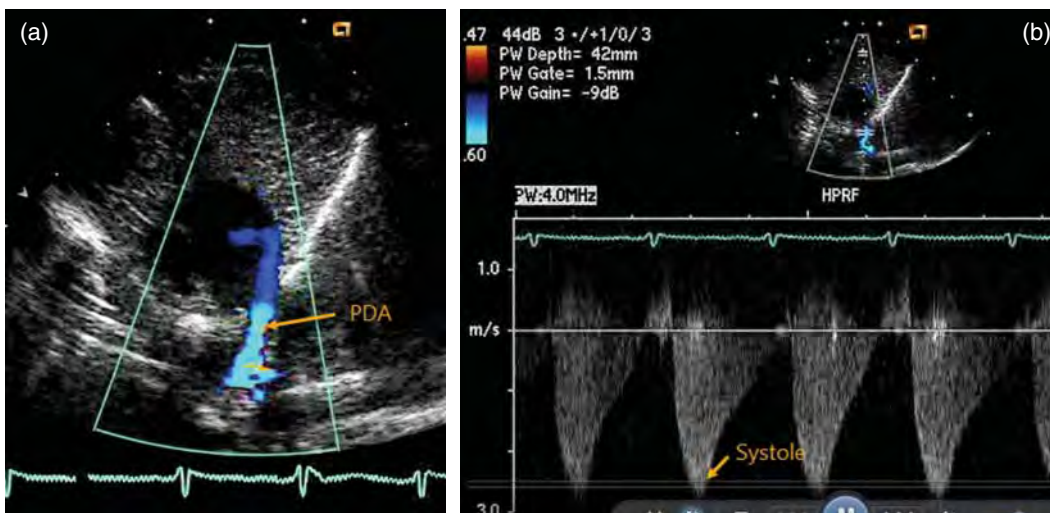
(a) Patient with pulmonary hypertension and a small PDA. (b) Spectral Doppler image demonstrates accelerated peak right to left systolic flow that terminates at mid-diastole.
